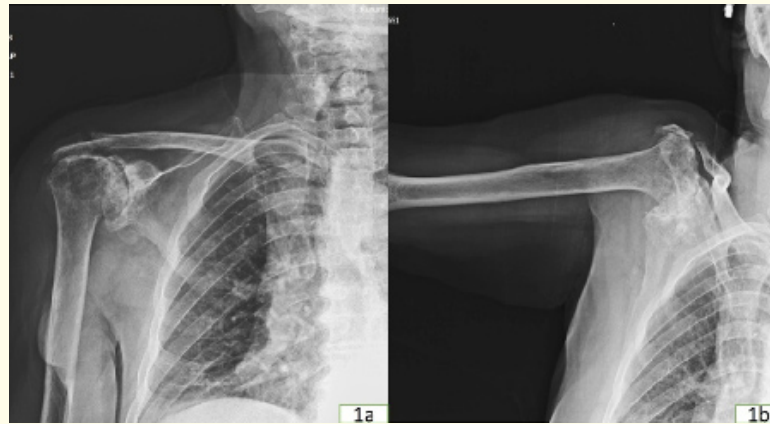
Preoperative anterior posterior radiograph.
